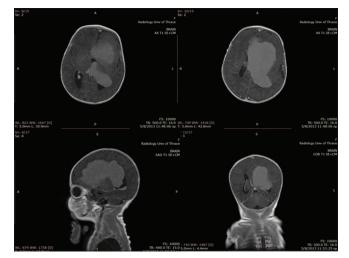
Magnetic resonance imaging scans with gadolinium showing marked and rather homogeneous enhancement after gadolinium administration while part of the frontal lobe (straight gyrus) showed some peripheral enhancement indicative of local infiltration. A second smaller lesion of 4 mm was shown at the choroid plexus of the left lateral ventricle.
